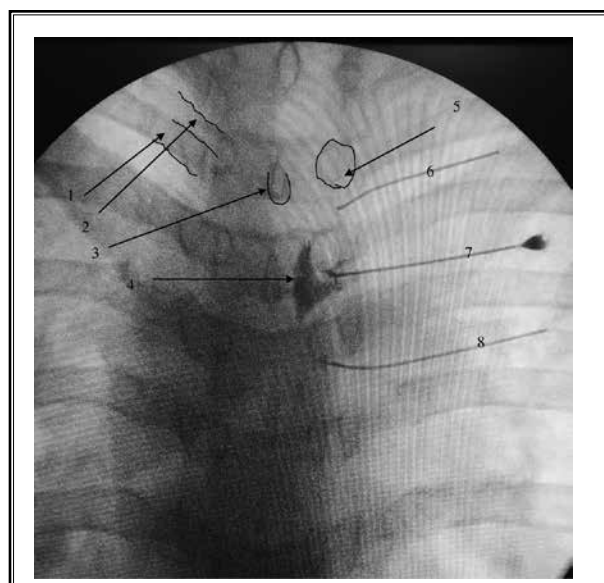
An A-P x-ray view of the upper thoracic spine depicting the DRG procedure. 1 = the transverse process of the second thoracic spine. 2 = the second rib. 3 = the spine of the second thoracic vertebra. 4 = dye delineating the transforaminal epidural. 5 = the pedicle of the second thoracic vertebra. 6, 7, and 8 = the RF needles targeting the second, third, and fourth thoracic DRG, respectively.
